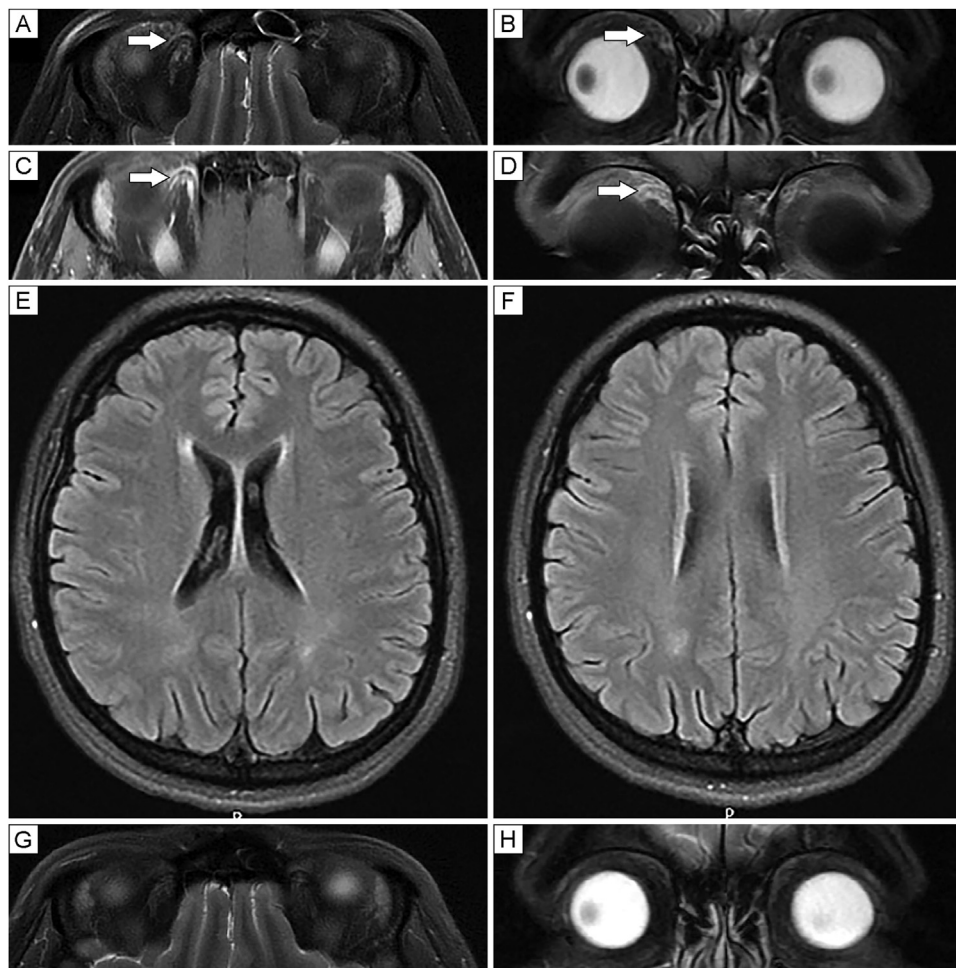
Cranio-orbital magnetic resonance imaging at day 1 of admission (A-F) and at 2 months' follow-up (G-H). Axial (A) and coronal (B) T2-weighted images demonstrate hyperintensity and thickening at the trochlea and anterior part of the superior oblique muscle, with edema in the right orbit. Axial (C) and coronal (D) post-contrast T1-weighted images with fat suppression showing abnormal contrast enhancement at the trochlea and anterior part of the superior oblique muscle in the right orbit (arrow). Axial flair images (E-F) of the brain demonstrate nonspecific hyperintensities in the periventricular white matter of the parietal lobes. Axial T2-weighted (G), and coronal T2-weighted (H) images show complete resolution of the previous high-signal intensity and thickening of the trochlea and anterior part of the superior oblique muscle in the right orbit.
